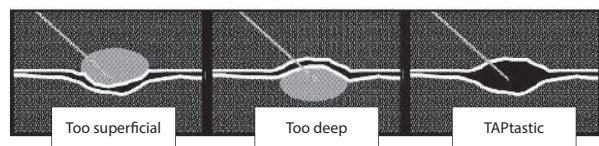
Figure highlighting the optimal needle position during ultrasound-guided TAP/IHN blocks.
